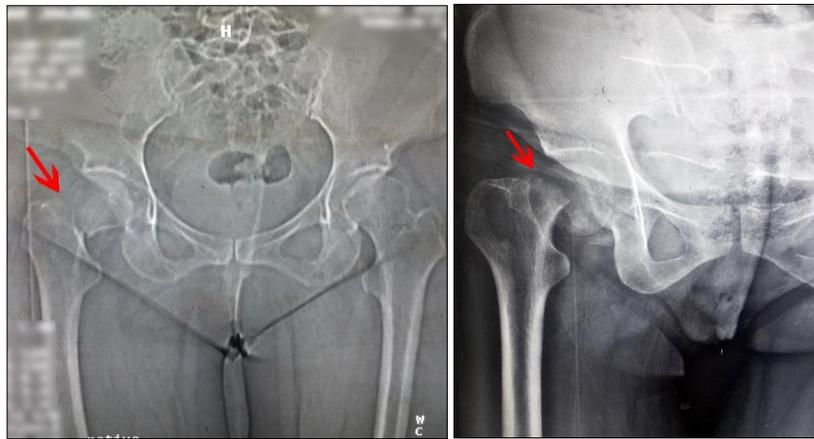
AP X-ray of two patients with Garden's class III (left) and class IV (right) femoral neck fractures indicated by the red arrow.
